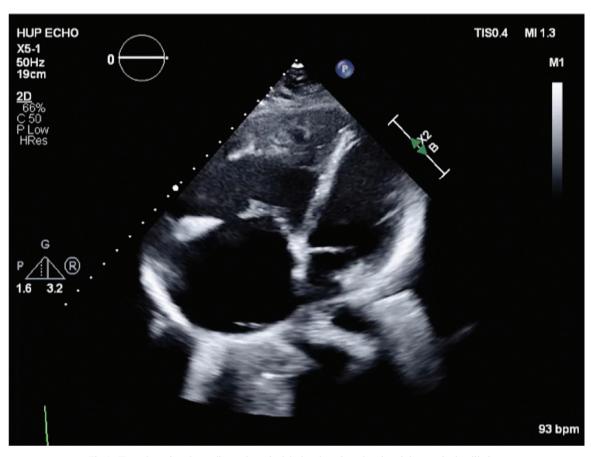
Transthoracic echocardiography apical 4-chamber view showing right ventricular dilation.
